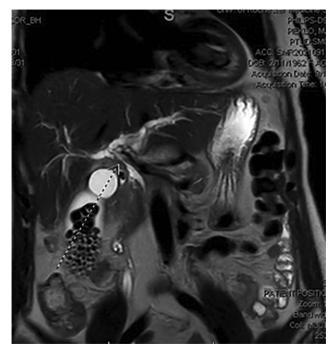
Magnetic resonance imaging showing intrahepatic ductal dilation with cutoff at the hilum and prominent perihilar soft tissue.
